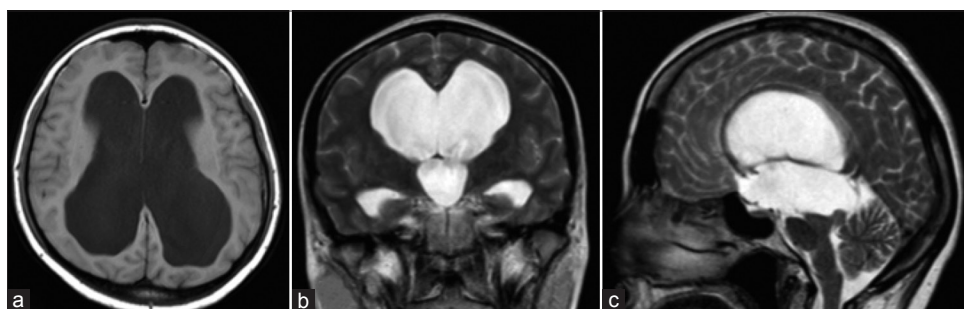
Hydrocephalus secondary to cerebral aqueduct obstruction is seen on T1-weighted axial (a), T2-weighted coronal (b) T2-weighted sagittal brain magnetic resonance images (c)
